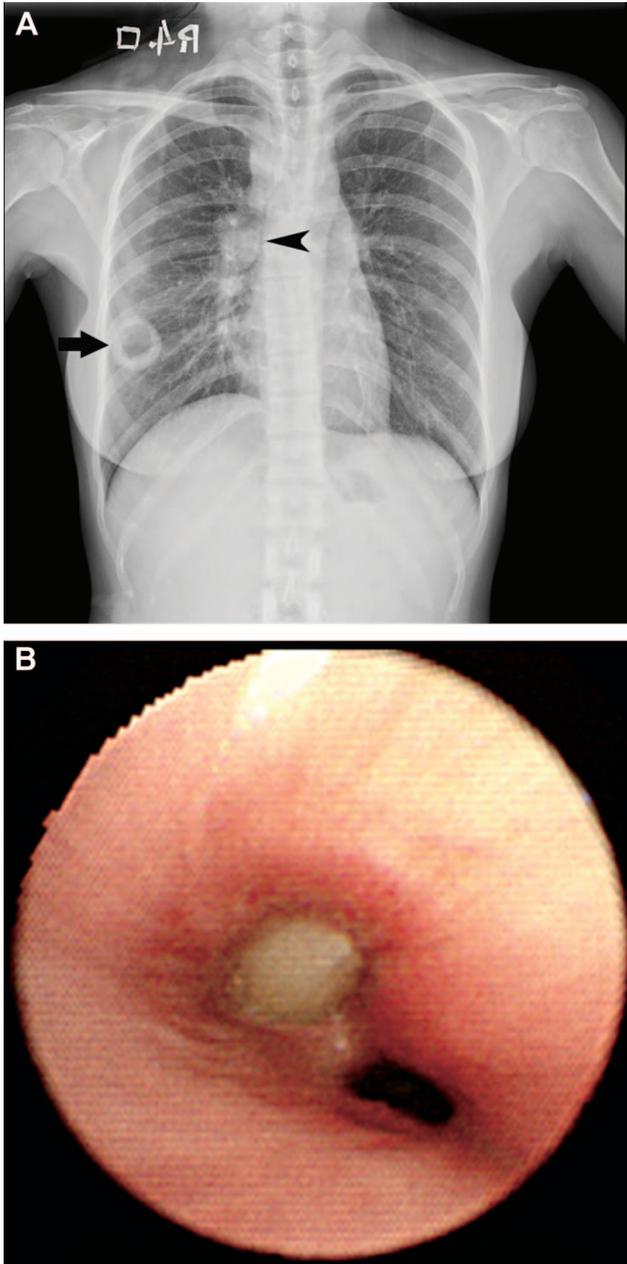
A, Chest radiography showed a 30 × 30 mm cystic lesion in the right lower lung with ipsilateral hilar enlargement. B, Bronchoscopic examination revealed an endobronchial mass at the orifice of the right lower lobe.
